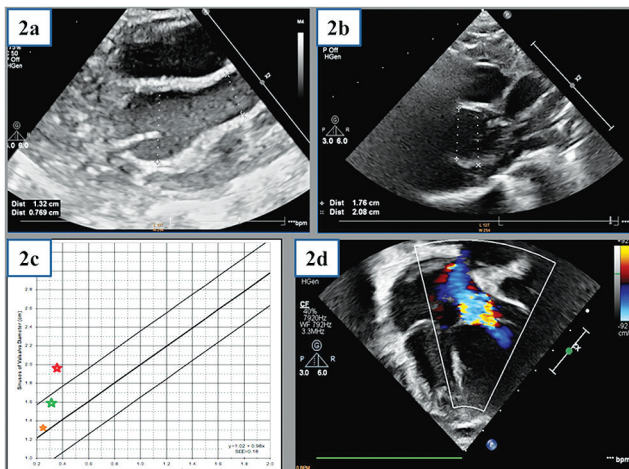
2D Echocardiography findings
